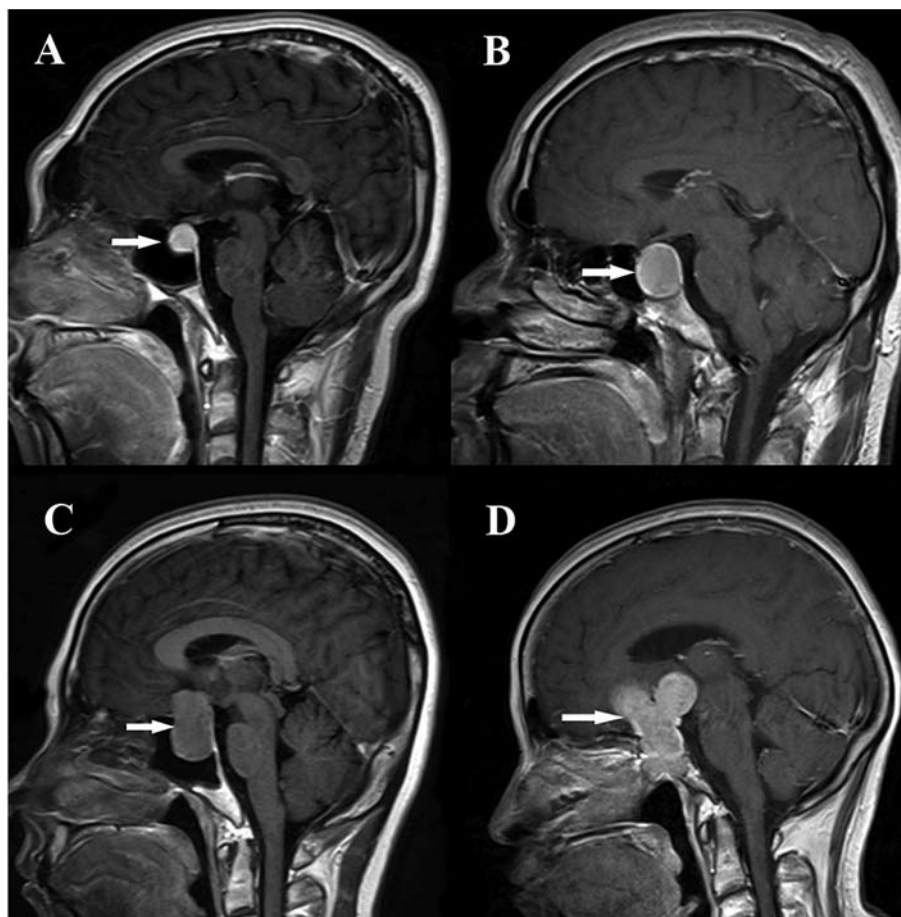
MRI images of typical cases of Hardy's stage I-IV (A-D, respectively), with stepwise increasing levels of Mammalian Target Of Rapamycin (*mTOR*). Regulatory associated protein of *mTOR* (*RAPTOR*) and Rapamycin Independent Companion of *mTOR* (*RICTOR*). White arrowhead indicates the tumour.
